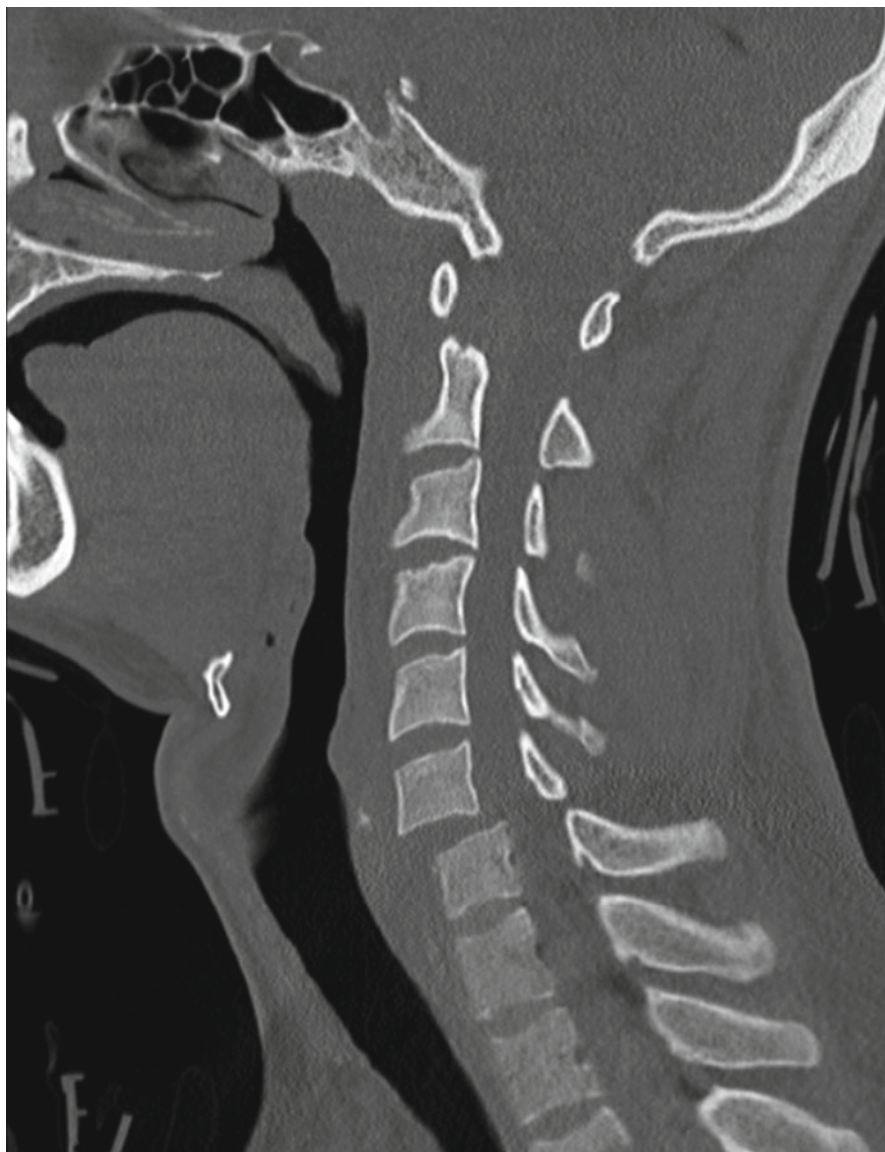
Sagittal CT scan demonstrating bi-facetal dislocation of C6 vertebra over C7 (Courtesy of Shibu P. Krishnan, London, UK)
